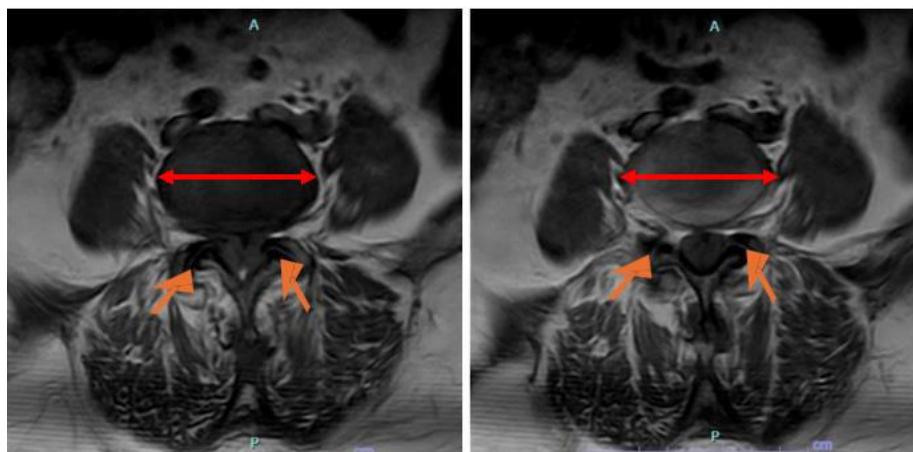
MRI Sequence (eAx_T1_TSE) Red marking indicates posterior broad-based protrusion along with orange arrows indicating significant narrowing of bilateral neural foramina
